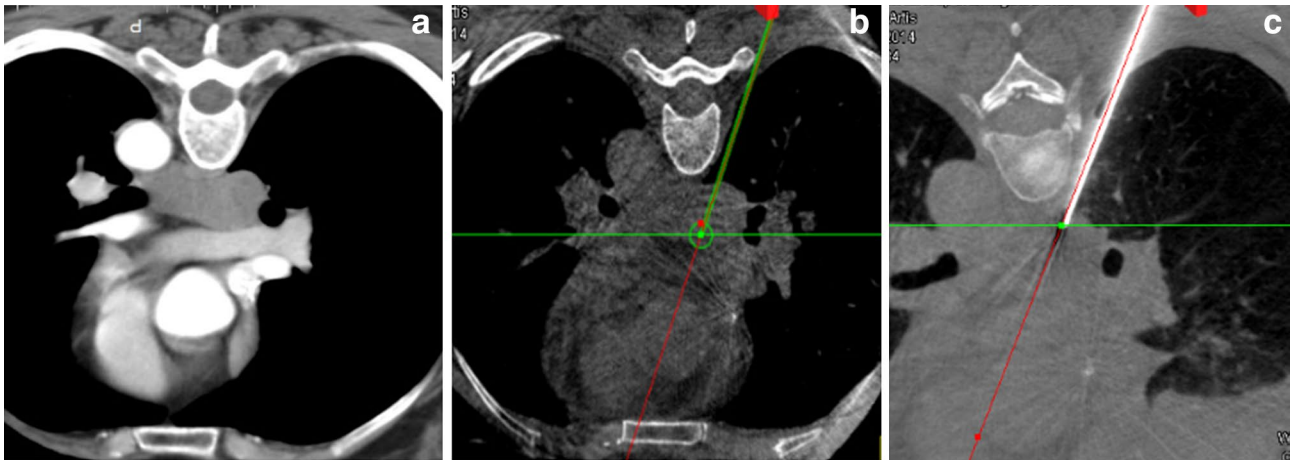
58-year-old patient, preoperative CT showed a 3.5 cm lesion in posterior mediastinum (a). CBCT images with graphics showing planned needle path (green line) into target lesion (green circle) (b). CBCT scan confirmed the needle position (c)
